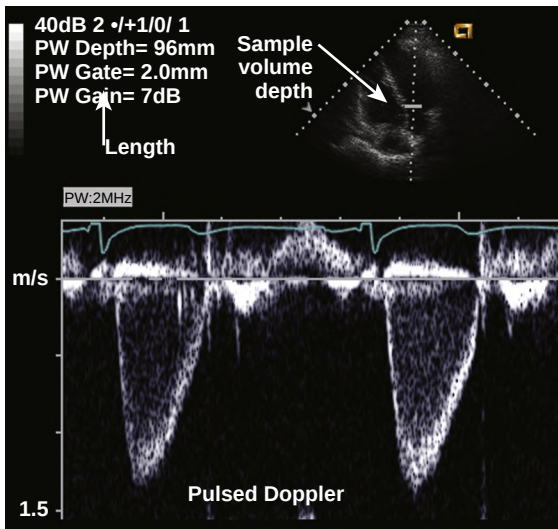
Doppler spectral tracing. LV outflow velocity was recorded with pulsed Doppler ultrasound from the apex. The sample volume depth (time for transmission and reception of the signal) is shown on a small 2D image with the length (sampling duration) indicated by the pulsed wave (PW) gate size. The spectral tracing shows time (horizontal axis), velocity (vertical axis), and signal strength (gray scale). The baseline has been shifted upward to show the entire velocity curve directed away from the transducer. Some diastolic LV inflow is seen above the baseline, directed toward the transducer.
